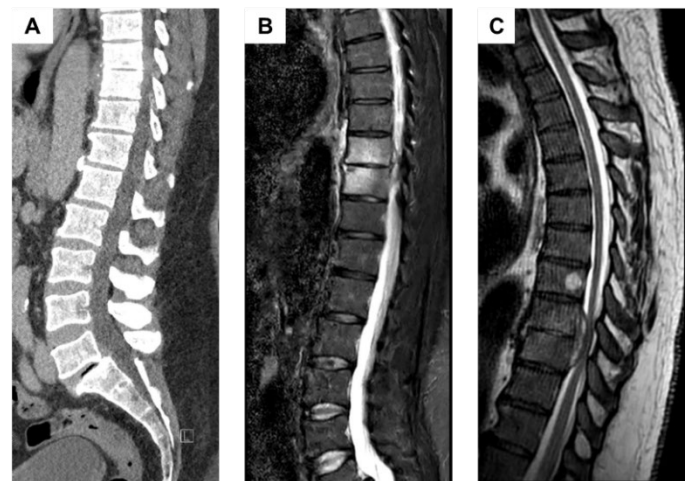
(A) No evidence of spondylodiscitis on CT. (B) MRI revealed spondylodiscitis at T9/10 with marked vertebral marrow edema, and (C) epidural abscess along the posterior vertebral margin, causing significant left paramedian spinal cord compression.
